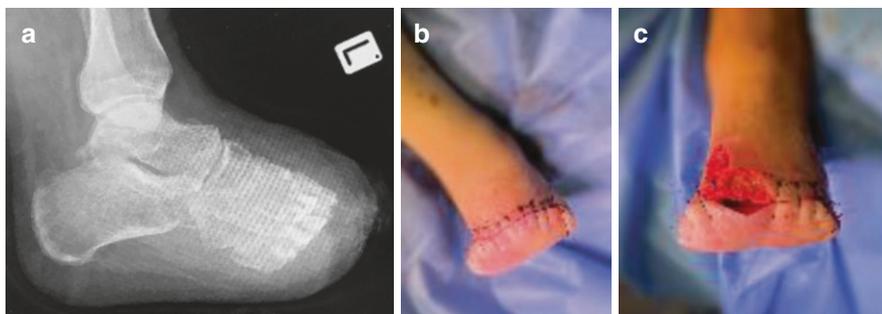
(a) Post-operative lateral radiograph of the foot following a trans-metatarsal amputation at the proximal shaft level. In this case example, a local antibiotic eluting injectable calcium preparation was injected into the medullary cavities of all metatarsal stumps, to prevent recurrence of infection. (b) Clinical photograph showing complete wound closure of trans-metatarsal amputation stump using a plantar flap. (c) Clinical photograph showing partial wound closure of trans-metatarsal amputation stump using a plantar flap. NPWT was applied
